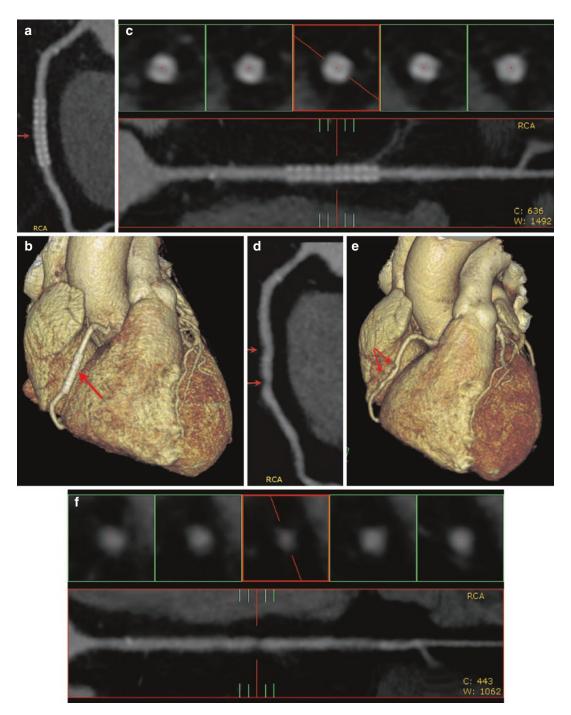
(a–c) cMPR, 3D volume rendering, and stretched: Patent RCA stent (*arrow*). (d–f) Pre-intervention CTA: RCA high-grade stenosis (*arrow*)
